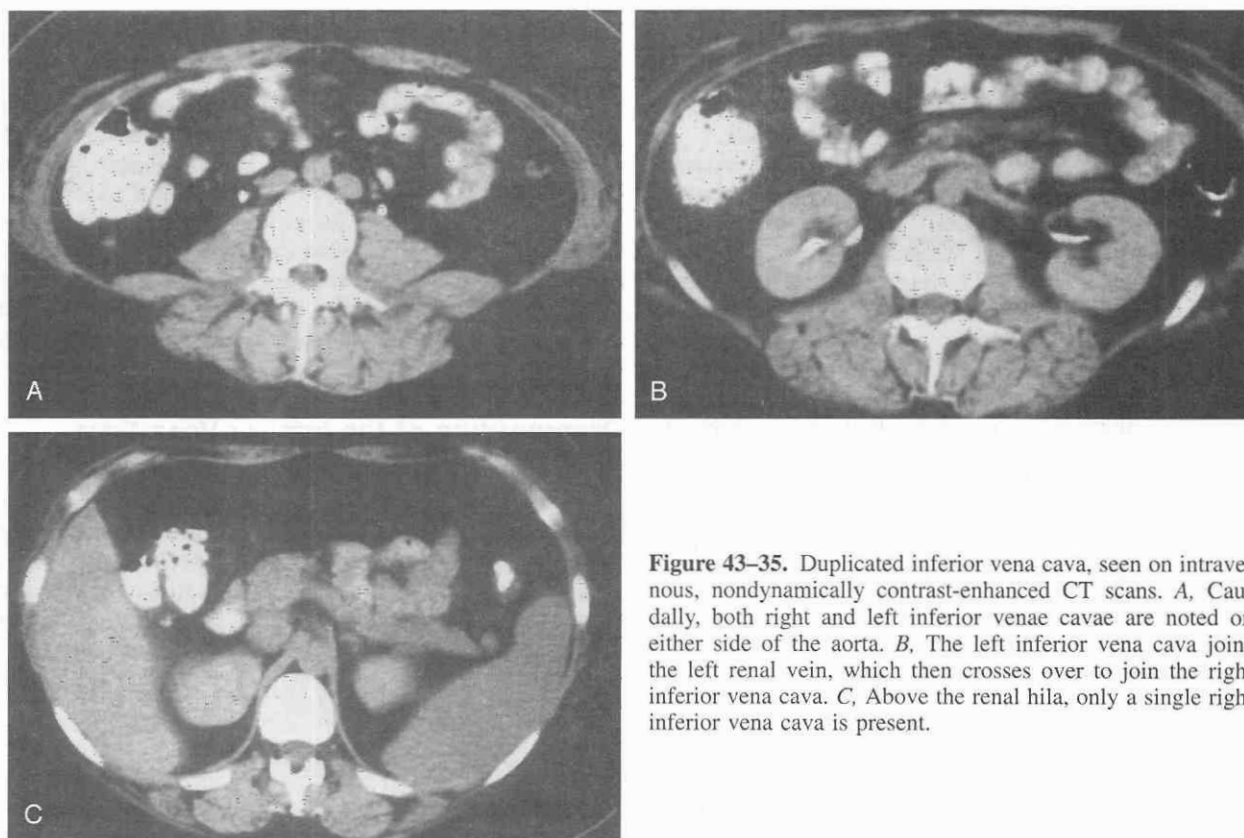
Duplicated inferior vena cava, seen on intravenous, nondynamically contrast-enhanced CT scans. *A*, Caudally, both right and left inferior venae cavae are noted on either side of the aorta. *B*, The left inferior vena cava joins the left renal vein, which then crosses over to join the right inferior vena cava. *C*, Above the renal hila, only a single right inferior vena cava is present.
